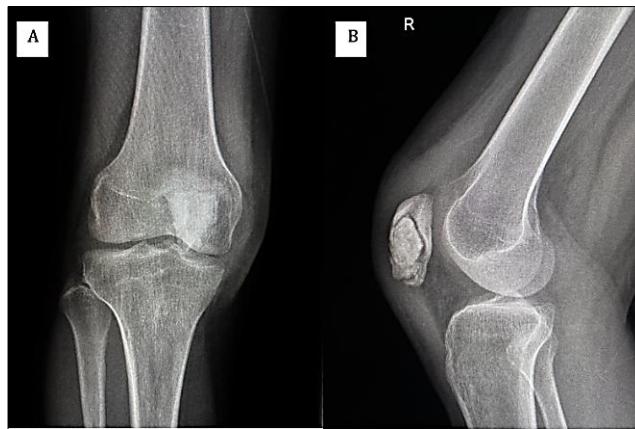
(A) Postoperative anteroposterior (AP) radiograph showing complete curettage and cavity reconstruction. (B) Postoperative lateral radiograph demonstrating adequate filling of the defect and restoration of patellar contours.
